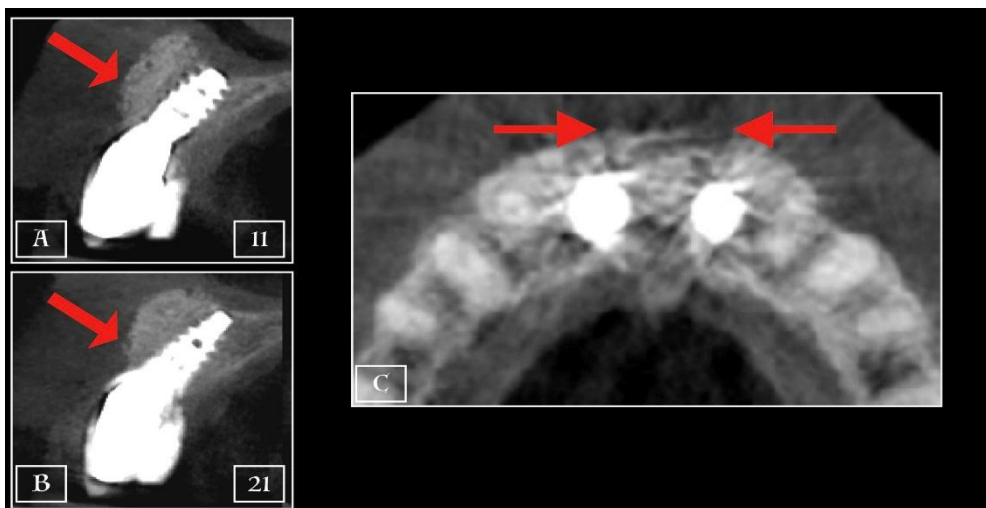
Follow Up CBCT done after 36 months showing well apposed bone completely covering both the implants homogenously
